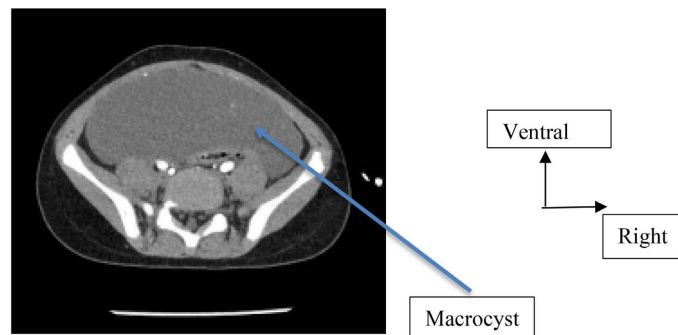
CT scan of an abdominal cystic lymphangioma.
